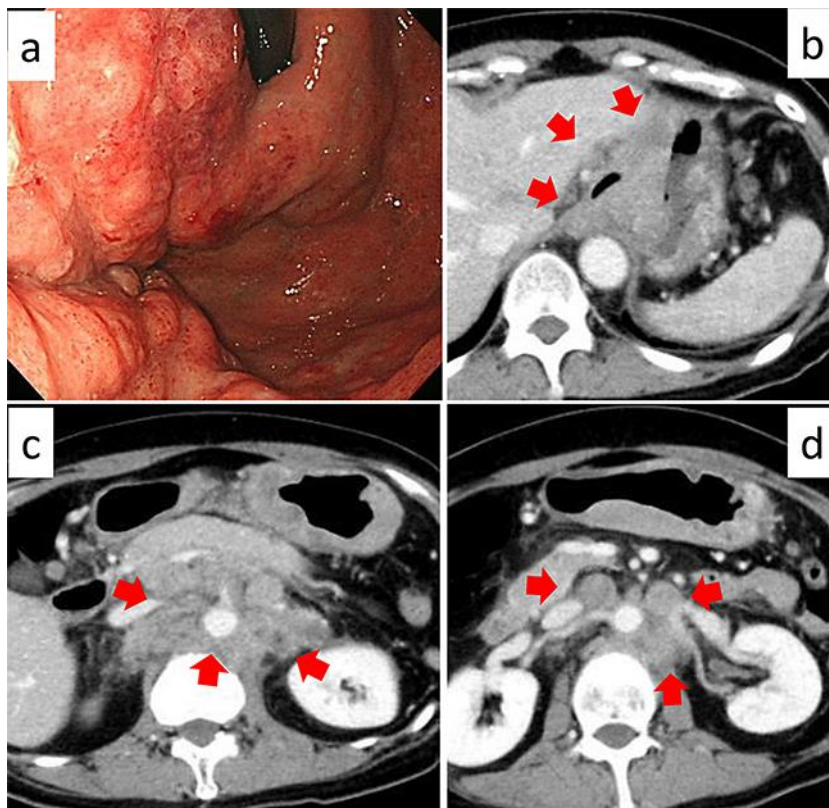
a Gastroscopy showed thickened wall in the antrum area, and spread proximally to the cardia. b, c CT showed high density of fat around the gastric and swelling of para-aortic lymph nodes, and bilateral adrenal metastasis (red arrows).
